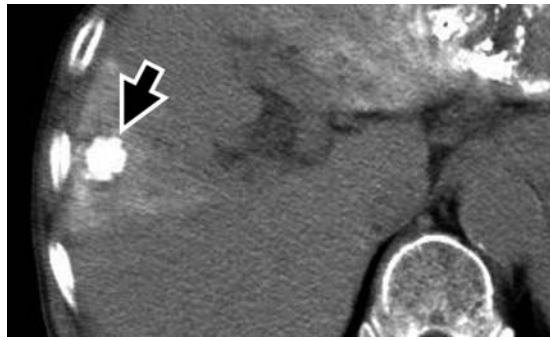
A 69-year-old man with a 1.1-cm HCC in the right hepatic lobe. (A) Iodized-oil CT shows complete iodized oil retention in the tumor (arrow). (B, C) DWI before (B) and after (C) TACE displayed on the Functool workstation monitor. Regions of interest were placed in the tumor (arrow) and surrounding hepatic parenchyma (arrowhead). DWI shows hyperintense signals in tumor both before and after TACE (arrow). ADC in HCC was higher after TACE ($3.45 \times 10^{-3} \text{ mm}^2/\text{s}$) than before TACE ($1.15 \times 10^{-3} \text{ mm}^2/\text{s}$) (%ADC, 200%). Mean ADC in surrounding hepatic parenchyma ($1.15 \times 10^{-3} \text{ mm}^2/\text{s}$) resembled that of HCC before TACE ($1.15 \times 10^{-3} \text{ mm}^2/\text{s}$). (D) Contrast-enhanced CT at 3 months after TACE depicted only complete iodized oil retention and no relapse of tumor (arrow).
